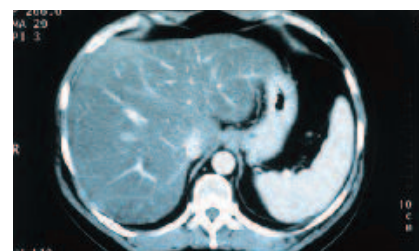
CT scan showing decrease in density of the liver in relation to the spleen.
